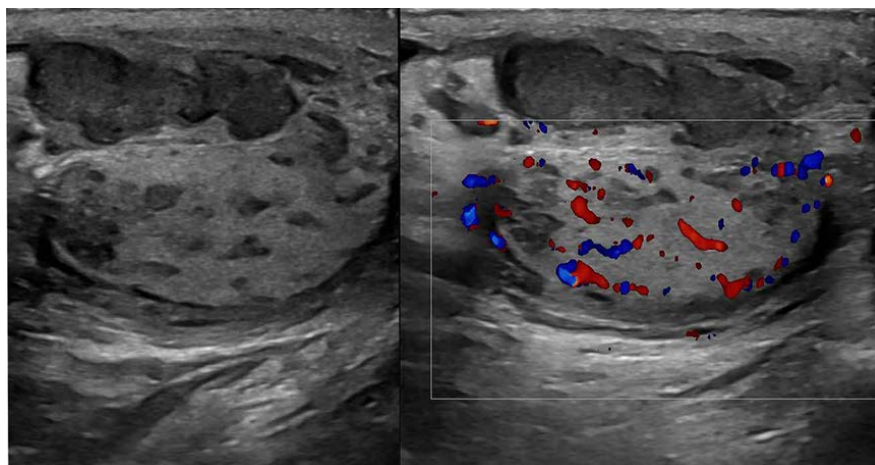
Ultrasound image of the patient's left testis after re-presentation 2 years after defaulting referral to the infectious diseases team. (A) The testis appears hyperechoic, with increased vascularity and with multiple hypoechoic nodules, in keeping with a miliary pattern of tuberculosis. The epididymis (E) is also bulky with an abnormal heterogenous hypoechoic appearance.
